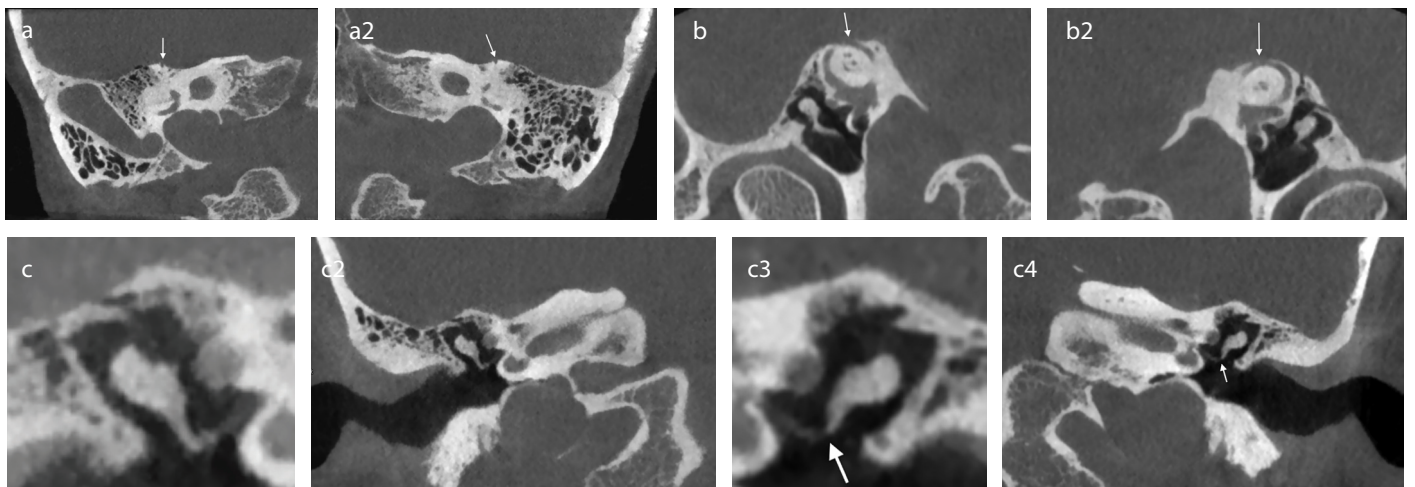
a-c. Cone beam computed tomography (CBCT) reformatted in the plane of Stenvers, perpendicular to the superior semicircular canal, showing the dehiscence of the bony roof of the right (left-hand panel) and left (right-hand panel) superior semicircular canal (arrows) (a). CBCT reformatted in the plane of Pöschl, perpendicular to the long axis of the temporal bone and in the plane of the superior semicircular canal, showing the entire extent of the defect (2.5 mm) (arrow) on both sides (b). Reformatted coronal CBCT and close-up of the incudostapedial joint showing a lysis of the lenticular process of the left incus (arrow). In the left-hand panel, the intact right-sided incudostapedial joint is presented with a close-up of the normal joint in the inset (c).
